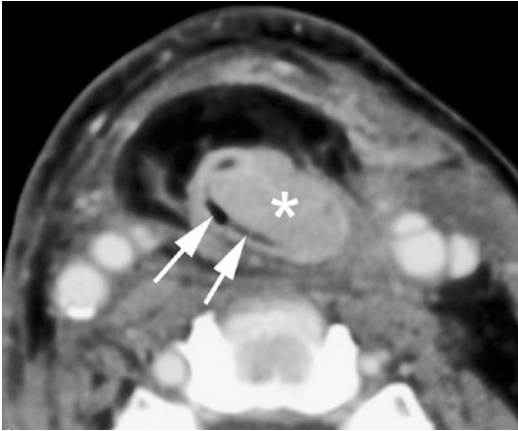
Axial contrast-enhanced CT image, after total laryngectomy for squamous cell carcinoma. Enhancing soft tissue mass (asterisk) at the anterolateral side of the neopharyngeal lumen (arrows): recurrent cancer
